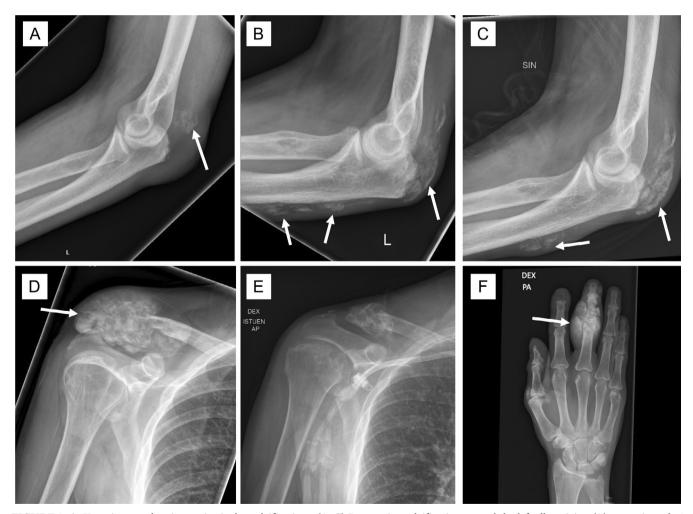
X-ray images showing periarticular calcifications. (A–C) Progressive calcification around the left elbow joint: (A) approximately 1 month after symptom onset, (B) 2 months later, and (C) 3 months later (arrows indicate calcifications). (D) Extensive calcific expansion in the right shoulder region with destruction of the lateral clavicle approximately 4 months after symptom onset (arrow indicates calcification). (E) Significant reduction of calcifications on a follow-up radiograph 10 months later. (F) Large calcified tumorous mass in the area of the right PIP-III joint (arrow).
